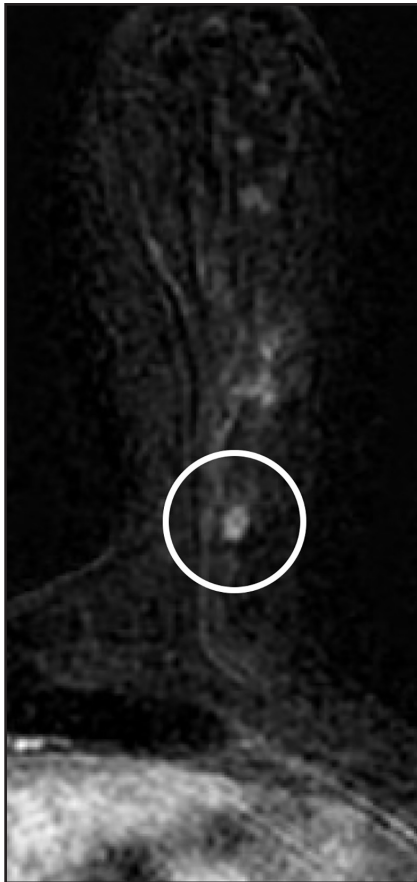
LCIS on MRI. Breast MRI examination demonstrates NME in the lower outer quadrant left breast. Biopsy performed under MR guidance yielded LCIS.
